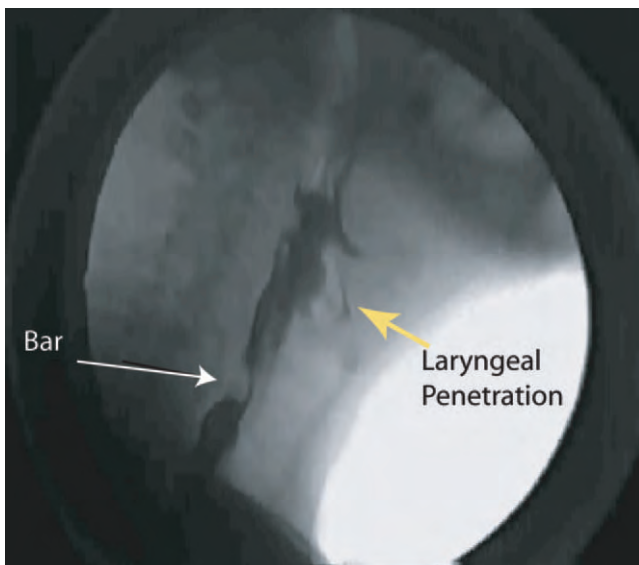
Barium contrast roentgenogram of pharyngeal swallowing activity showing a prominent cricopharyngeal indentation (*white arrow*) in a patient with dysphagia resulting from bulbar poliomyelitis. The patient also showed evidence of laryngeal penetration (*yellow arrow*).
